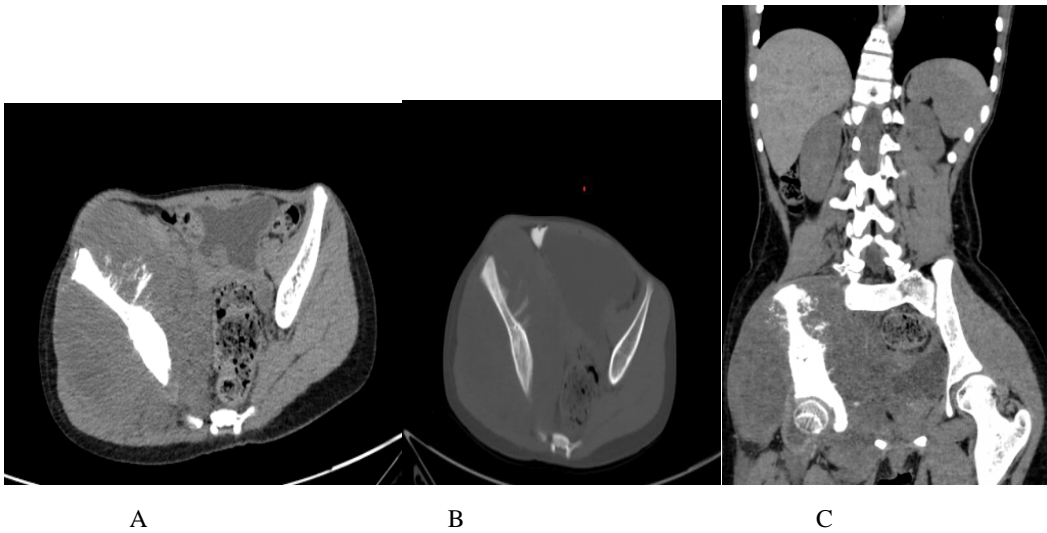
CT abdomen showing large mass occupying whole peritoneal cavity. B & C. are post chemotherapy follow up scan suggestive of marked reduction in the size of the mass lesion.
